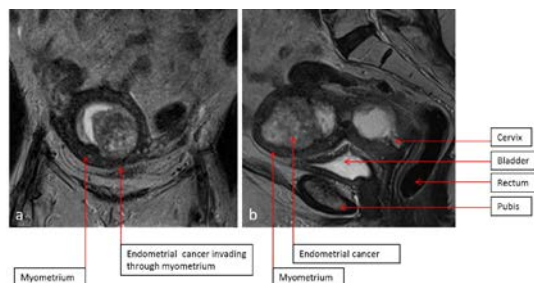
51-year-old female patient with biopsy proven endometrial carcinoma. Coronal plane at the level of the uterine fundus (a) and mid-sagittal plane (b) images from pelvic MRI demonstrate a large and heterogeneous endometrial mass consistent with the biopsy proven endometrial carcinoma, extending into the endocervical canal. Note the presence of deep myometrial invasion at the level of the fundus (a). Courtesy of University of Massachusetts Medical School, Abdominal Imaging Division, UMass Memorial Medical Center
